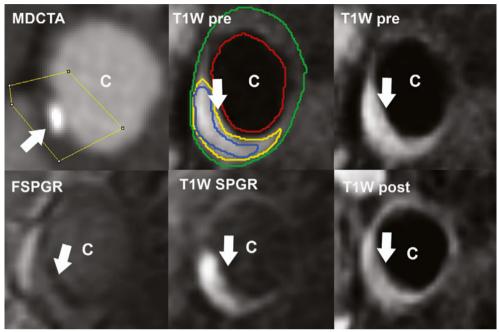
Example of how overshadowing of intraplaque hemorrhage on MRI have led to underestimation of calcifications on MRI compared to MDCTA. Corresponding MDCTA and MR images of a patient in which the mismatch between MDCTA and MRI (MDCTA calcifications present; MRI calcifications absent) can be explained by missing the calcification on MRI because overshadowing of the intraplaque hemorrhage (blue contour). C common carotid artery; arrow calcification.
